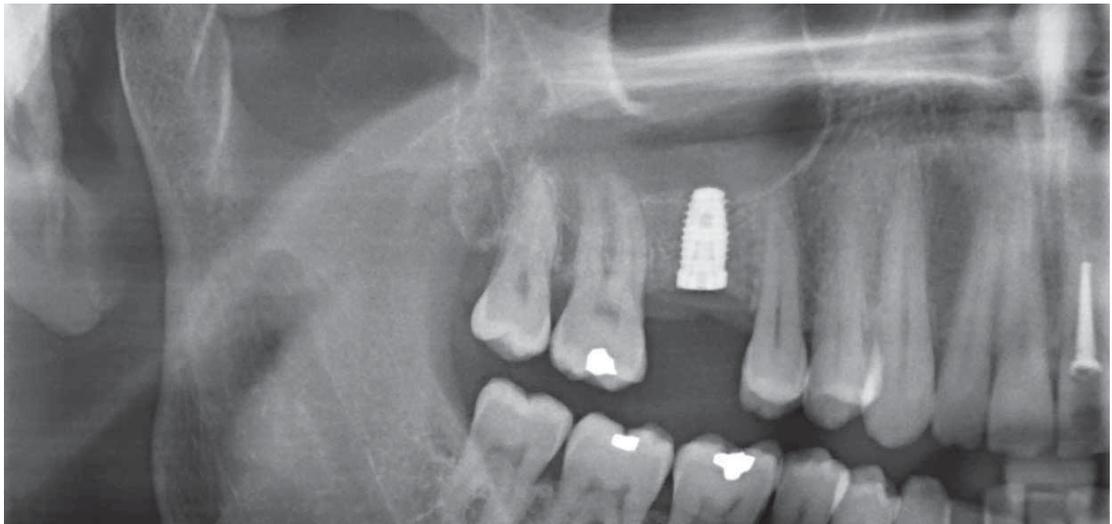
to 12 show the procedure for sinus elevation/GBR. Following the extraction of tooth 16, the remaining bone, with a bone height that was insufficient for implant placement, was augmented with a particulate xenogeneic BSM (CopiOs) and covered with a xenogeneic pericardial membrane. A significant reduction of the horizontal volume deficit was found after six months. The control radiograph after implant insertion at site 16 showed resorption of the BSM and the presence of clearly recognizable cortical bone towards the maxillary sinus.
